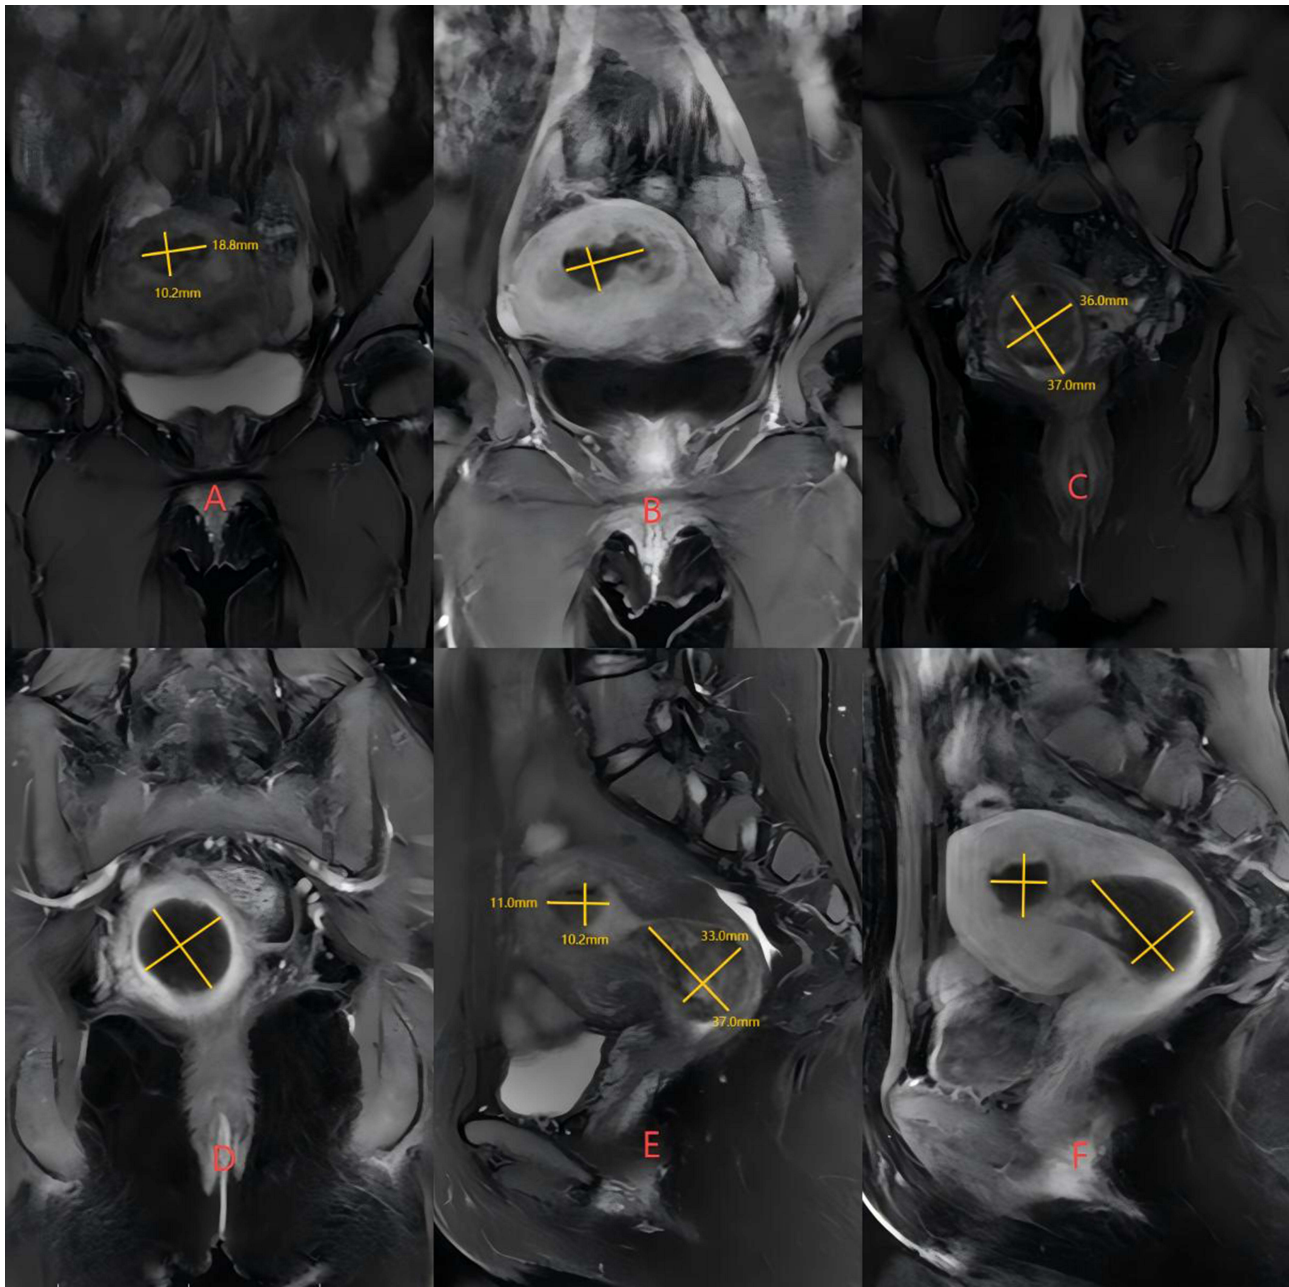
Magnetic resonance imaging of uterus after HIFU treatment (A,C and E). Uterine magnetic resonance imaging after contrast enhancement (B,D and F). The picture shows that uterine myoma is located in the cervical canal.
